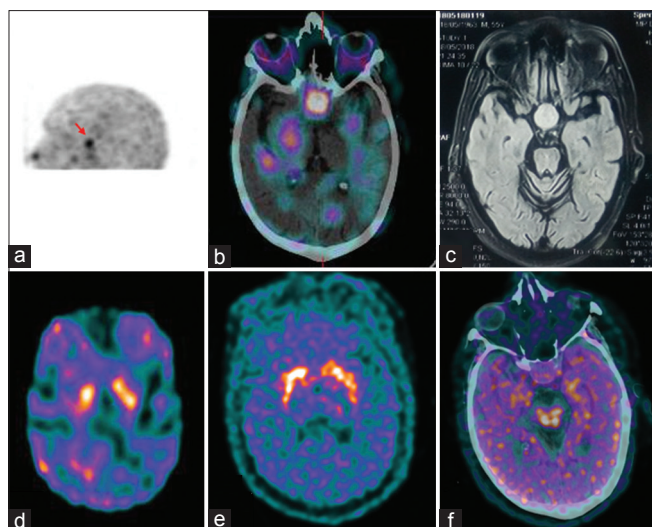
(a) Cine single-photon emission computed tomography image showing focal tracer accumulation, (b) corresponding to the pituitary macroadenoma on single-photon emission computed tomography/computed tomography, (c) pituitary macroadenoma as seen on magnetic resonance imaging, (d) labeled tropane derivatives single-photon emission computed tomography transaxial image showing normal uptake in the left basal ganglia and equivocal right basal ganglia uptake, (e) F-18 fluoro-dihydroxyphenylalanine positron emission tomography transaxial image showing normal uptake in both basal ganglia and, (f) F-18 fluoro-dihydroxyphenylalanine positron emission tomography image at sella level showing no uptake in the pituitary macroadenoma
